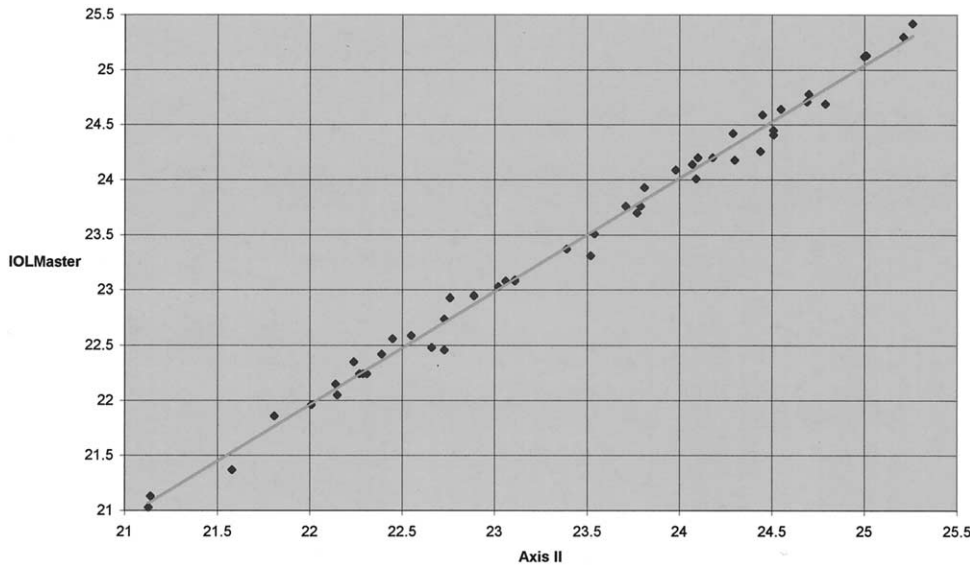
(Packer) Comparison of axial length measurements by immersion ultrasound (abscissa) and optical coherence interferometry (ordinate). The linear regression trend line reflects the high correlation between the 2 sets of values (correlation coefficient = 0.996).
